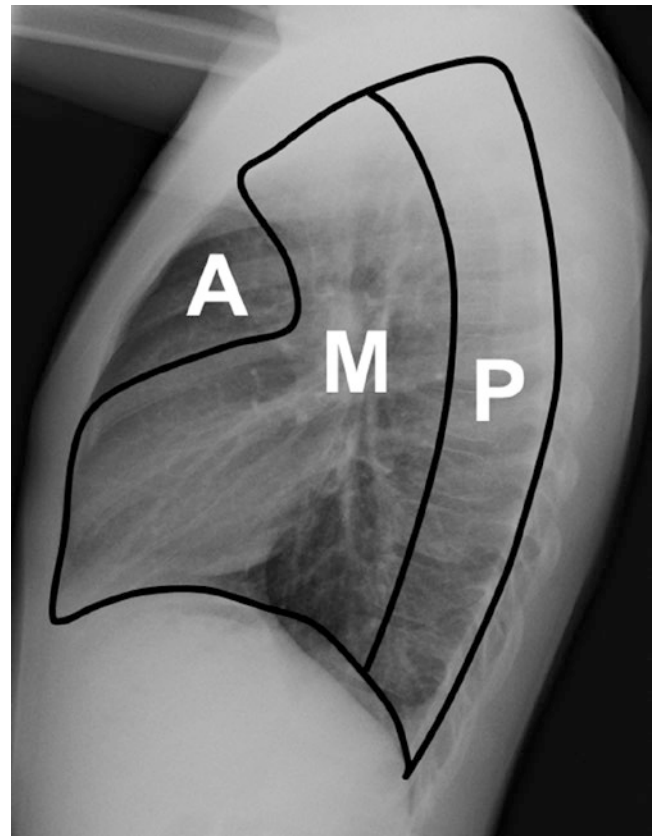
Lateral chest radiograph depicting the three mediastinal compartments, anterior (A), middle (M), and posterior (P). The anterior mediastinal compartment is the space bordered anteriorly by the sternum and posteriorly by the pericardium. The middle mediastinal compartment is the space between the anterior border of the pericardium and an imaginary line drawn approximately 1 cm posterior to the anterior border of the thoracic vertebral bodies. The posterior mediastinal compartment is the space bordered anteriorly by an imaginary line drawn approximately 1 cm posterior to the anterior border of the vertebral bodies and posteriorly by the posterior paravertebral gutters
